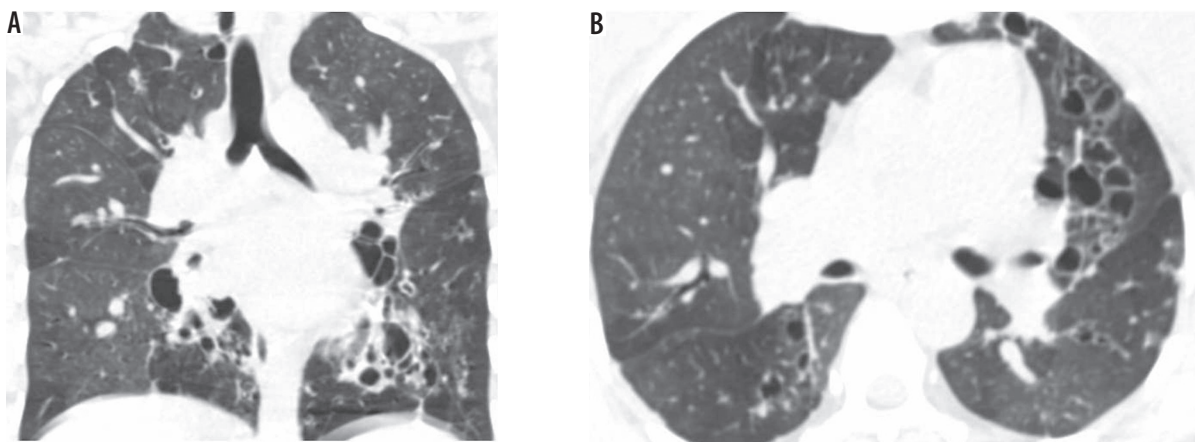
A) Coronal and (B) axial computed tomography lung window images showing varicose and cystic bronchiectasis in both lungs as a sequela of tuberculosis
